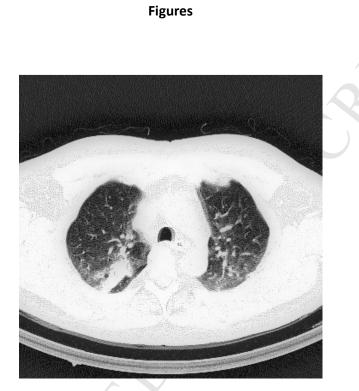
Axial low-dose CT demonstrating an incidental lung cancer detected on CT attenuation correction
